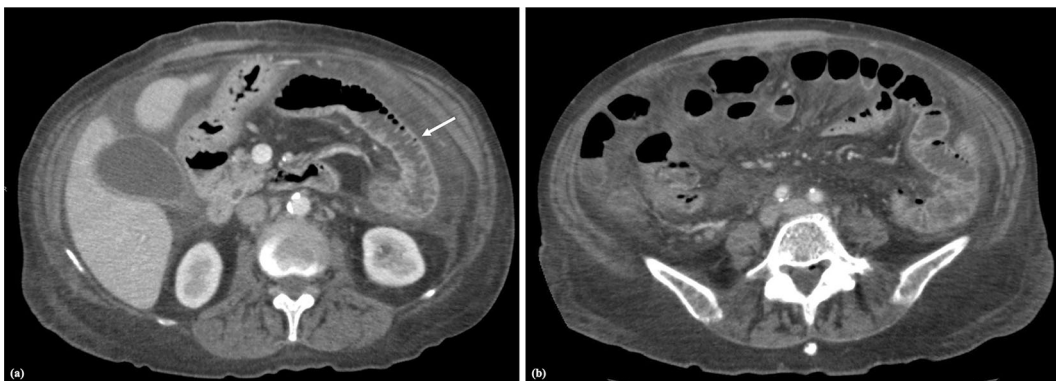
21-year-old woman who received chemotherapy for acute myeloid leukemia. Contrast enhanced axial CT scans show a jejunal wall hyperenhancement (arrow), severe
